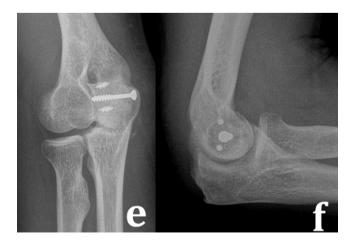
46 year-old patient with medial humeral epicondyle nonunion at the 3rd month follow-up: (a) post-operative antero-posterior radiograph; (b) post-operative lateral radiograph.
